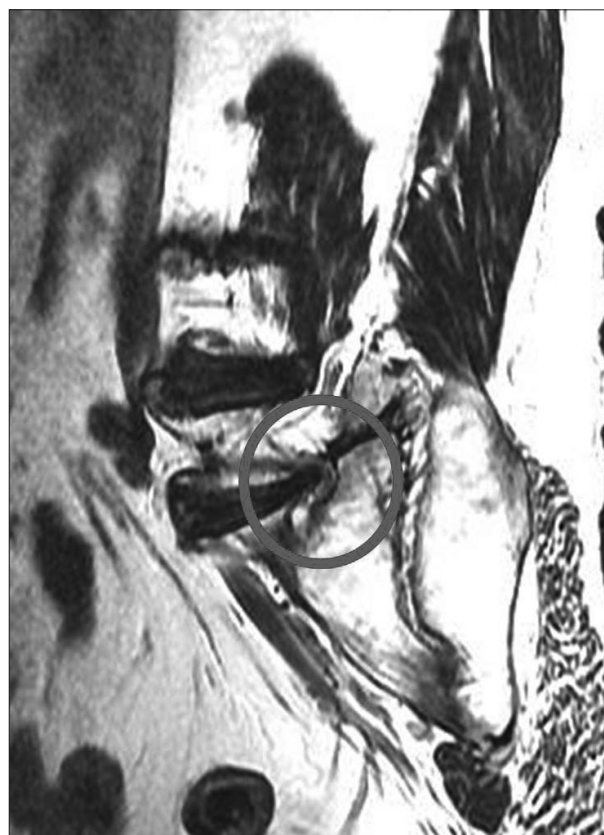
Foraminal view MRI of L5-S1 right side.
